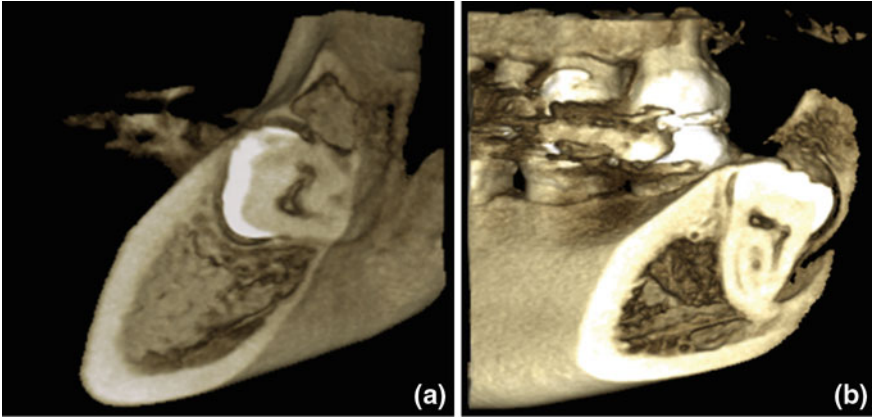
CBCT 3D reconstruction of mandibular *right* (a) and *left* (b) third molar
